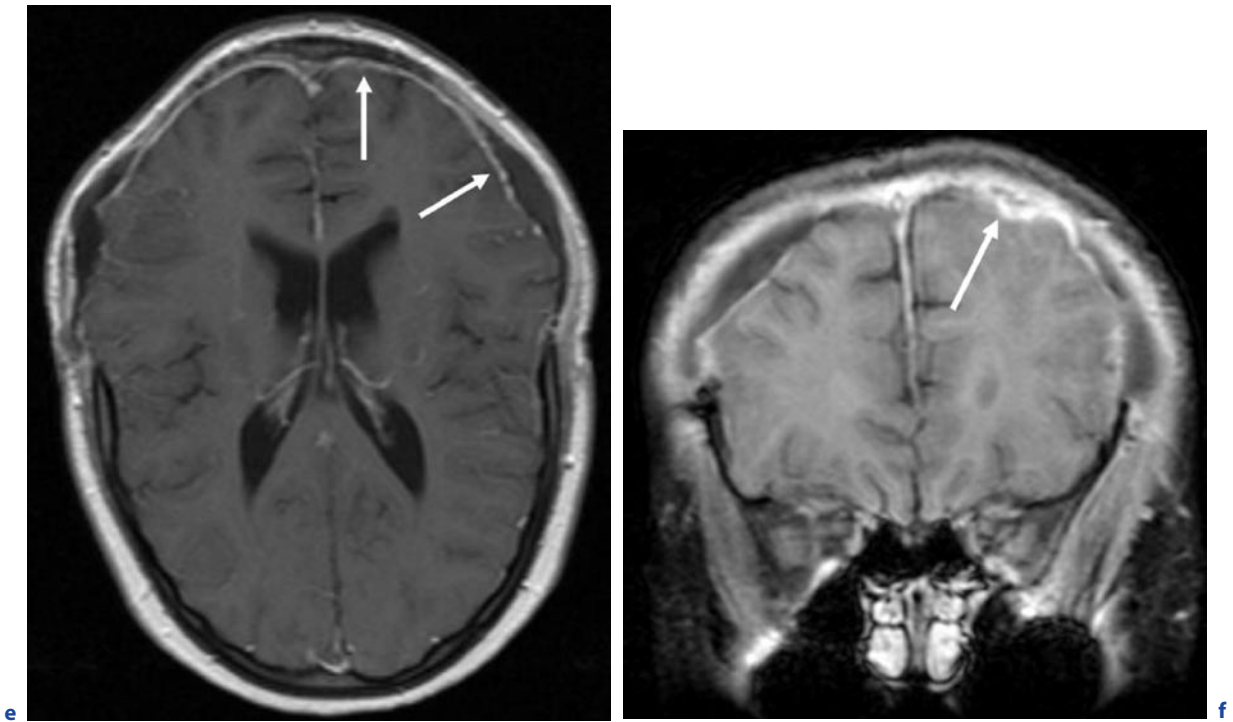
(continued) Pneumococcal meningitis with complicating epidural empyema. A 14-year-old girl that presented initially with clouded consciousness and recurrent generalized seizures due to meningococcal meningitis. Indication for bifrontal hemicraniotomy was made due to pronounced general brain edema. e Axial T1-weighted image after contrast administration after bifrontal hemicraniotomy. f Coronal T1-weighted image after contrast administration after bifrontal hemicraniotomy. Axial FLAIR images (c,d) show hyperintense
